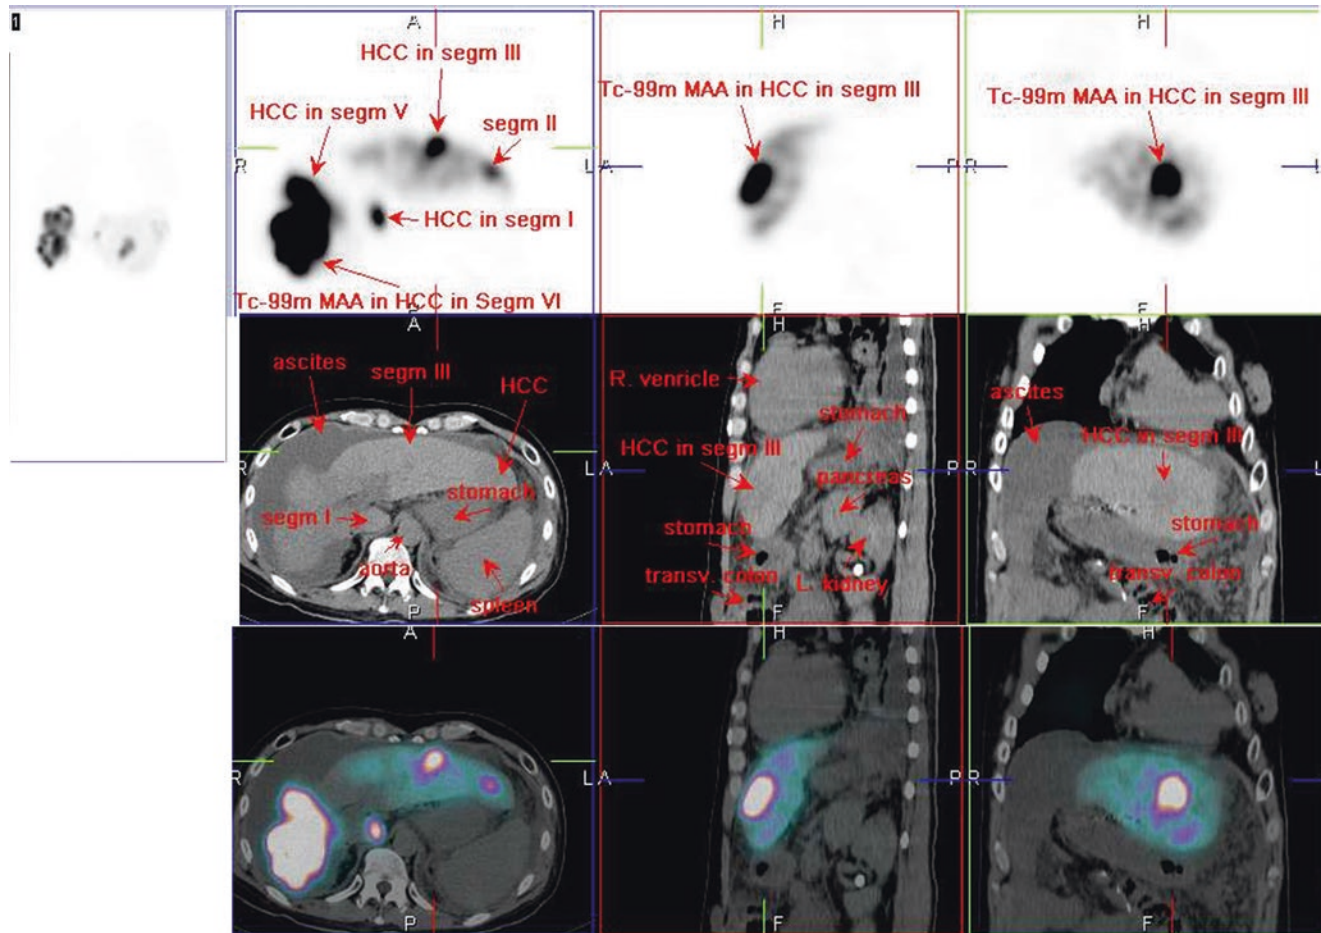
^{99m}Tc-MAA SPECT/CT
